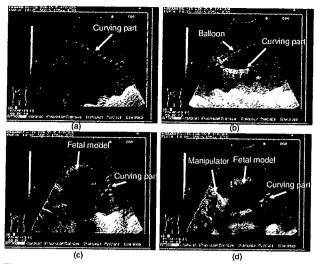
Ultrasound guided manipulator insertion in stabilizing the fetus model (a) the curving mechanism was observed clearly. (b) both of the curving mechanism and the swollen balloon were observed. (c) the fetus model and the manipulator is observed (d) The manipulator and the curving mechanism could be observed under the fetus model.
